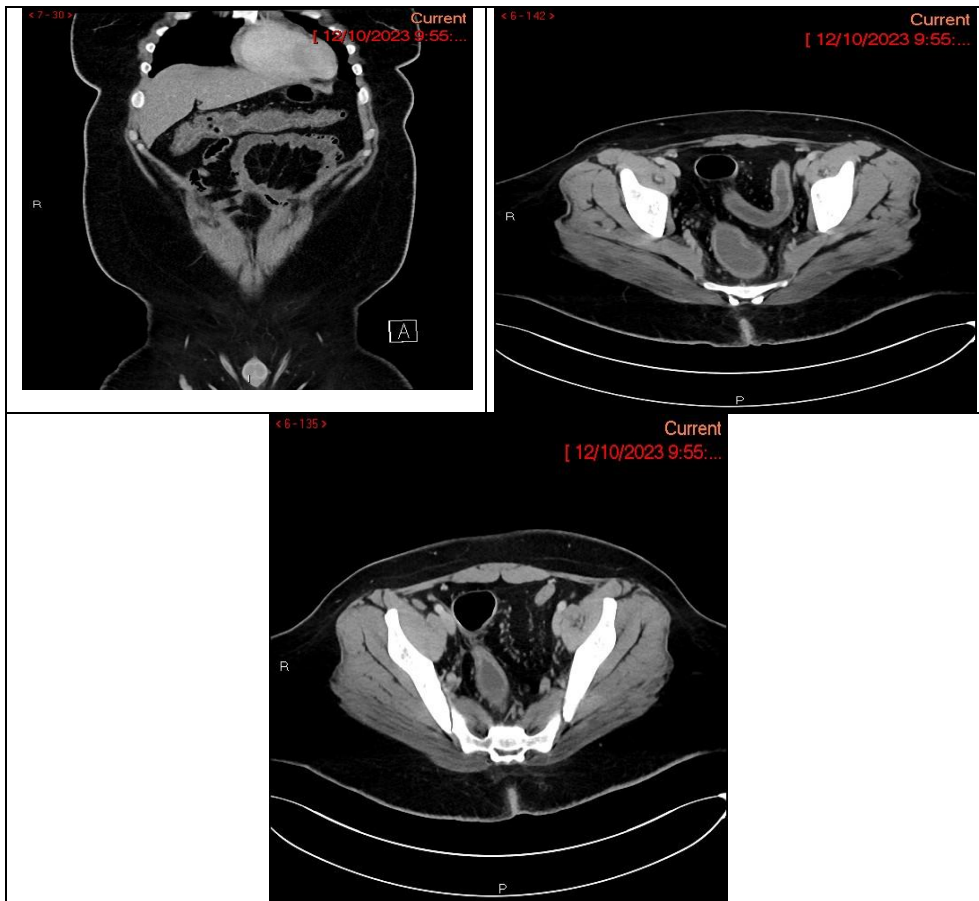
Coronal and axial CT scan with IV contrast revealed
